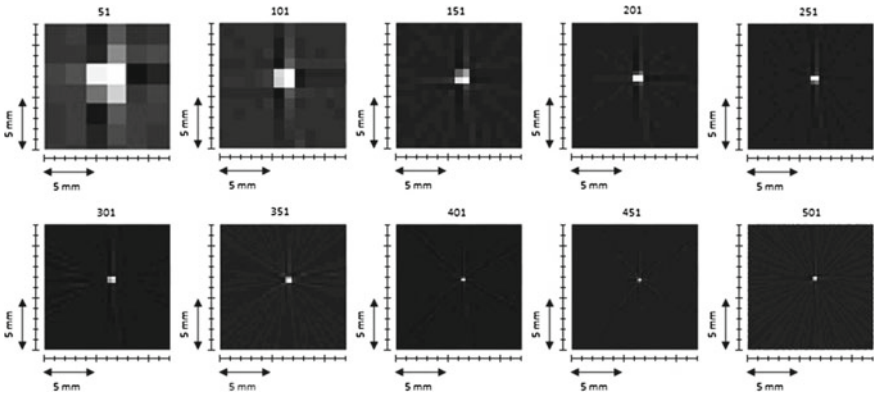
Image reconstruction for the number of Doppler bands in the range of 51 to 501
